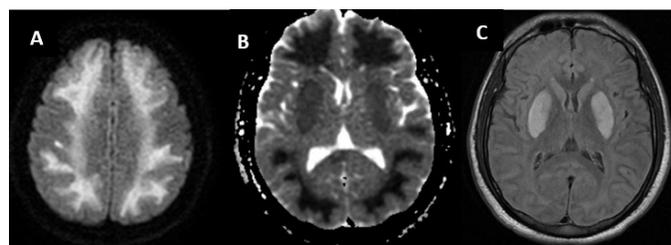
A 42-year-old female patient, methyl oxide intoxication, A, widespread deep white matter involvement in diffusion-weighted images magnetic resonance imaging (MRI), B, deep white matter involvement areas in ADC map MRI, C, bilateral putamen involvement in FLAIR MRI
